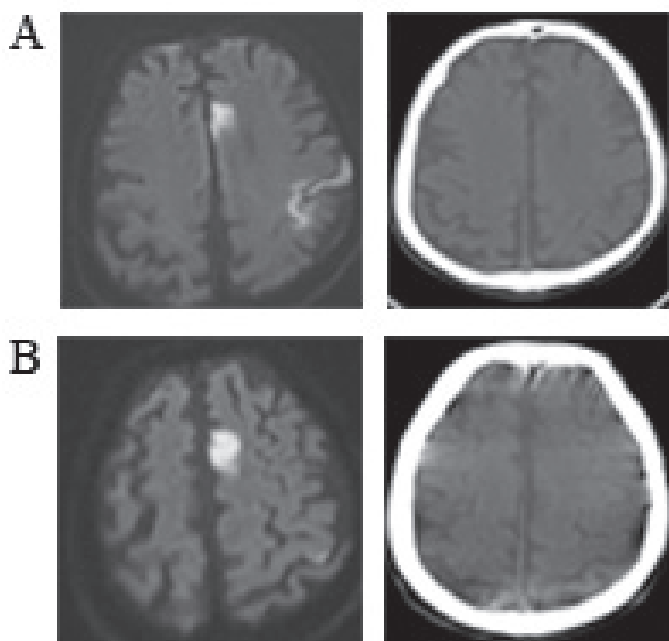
A) Pre-operative MRI and CT B) Post-operative MRI and CT
